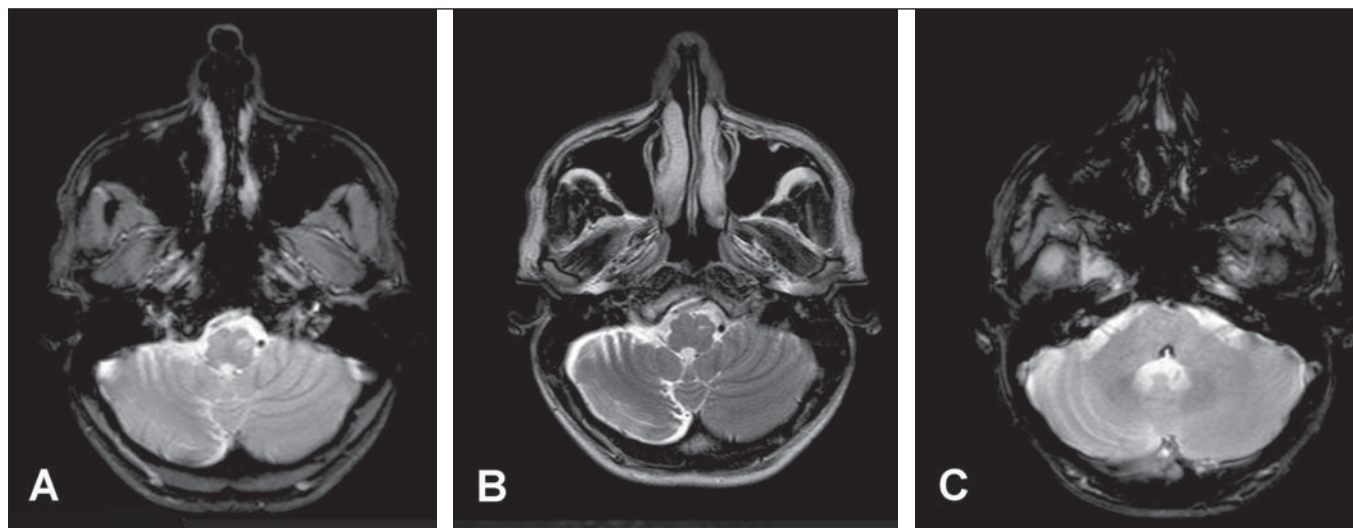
MRI of the brain. Axial, T2-weighted FFE image at the level of the bulb (A) and axial T2-weighted image (B) shows hypersignal in the region of the left inferior olivary nucleus, as well as accentuation of sulci in the right cerebellar hemisphere. Susceptibility-weighted imaging (C) at the level of the pons shows lesion with peripheral hypointensity in the pontine tegmentum (left facial colliculus), compatible with hemorrhagic focus.
